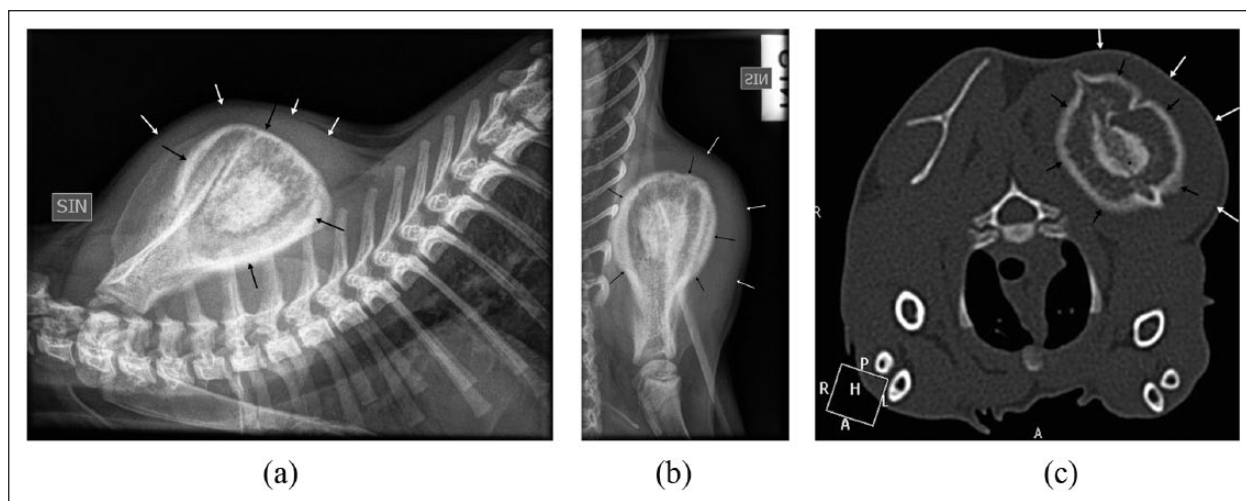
(a) Mediolateral projection of the left scapula showing the expansile lesion (black arrows) with adjacent soft tissue swelling (white arrows). (b) Caudocranial projection of the left scapula showing the marked expansion of the bone with aggressive periosteal reaction (black arrows), thickening of the cortex and surrounding soft tissue swelling (white arrows). (c) Transverse CT image (window level 500, window width 2000, slice thickness 1.0 mm) showing the expansile lesion (black arrows) with the central irregular heterogeneous mineral density. Surrounding soft tissue swelling (white arrows)
